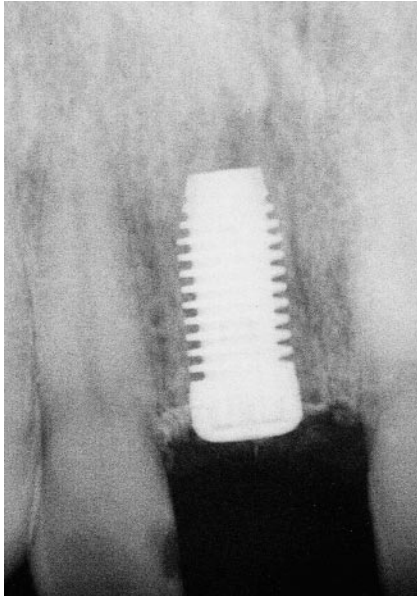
A periapical radiograph of the D2 implant body in the central incisor position.
